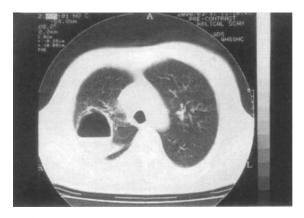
CT scan (single cut) of the upper thorax of patient MS showing marked progression of the lesion over 18 months, with no treatment, March 2000. Collectively these images show the evolution over 5 years from a very small cavity presumably from the *M. avium* infection, to the development of an aspergilloma, which expanded slowly to a huge cavity. He improved with antifungal therapy, although the cavity remains large.
